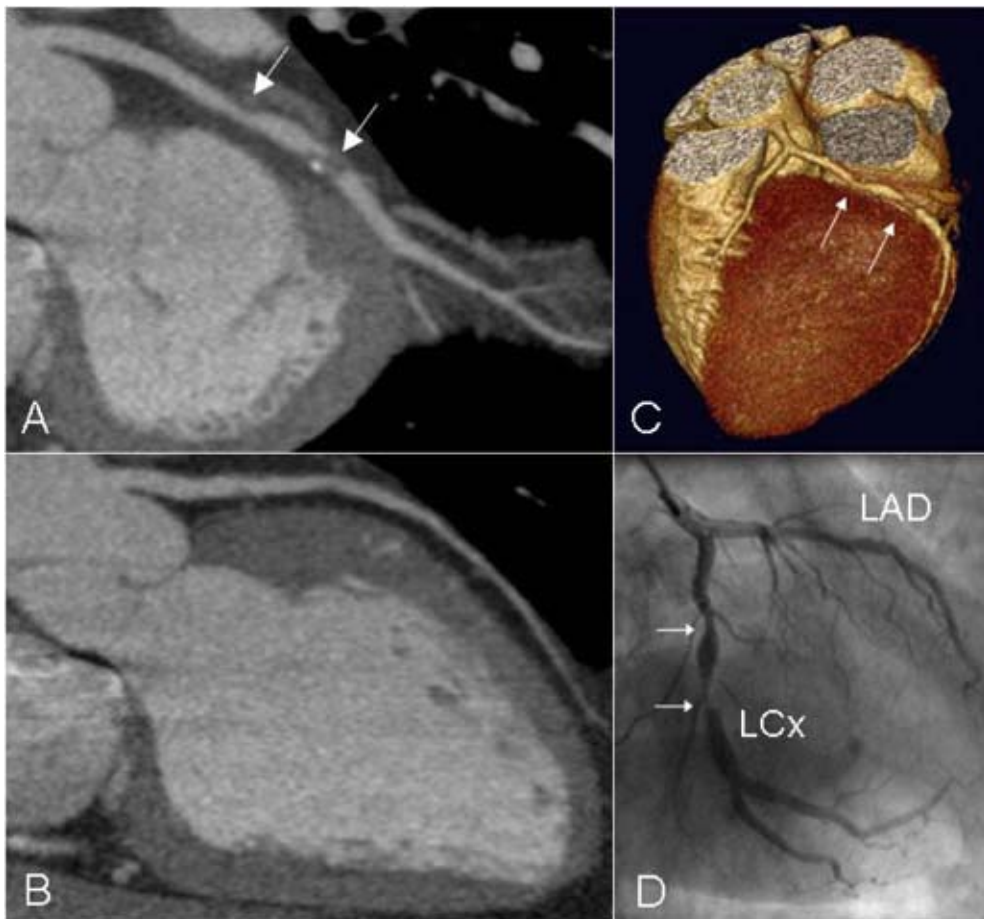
In panel A, a curved multiplanar reconstruction of a left circumflex coronary artery (LCx) with severe narrowing of the lumen is depicted. No abnormalities however were observed in the left anterior descending coronary artery (LAD) of this patient (panel B). Also, in the 3D volume rendered reconstruction (panel C), stenoses in the LCx as well as patency of the LAD are clearly visible. Findings were confirmed by conventional X-ray angiography (panel D).
